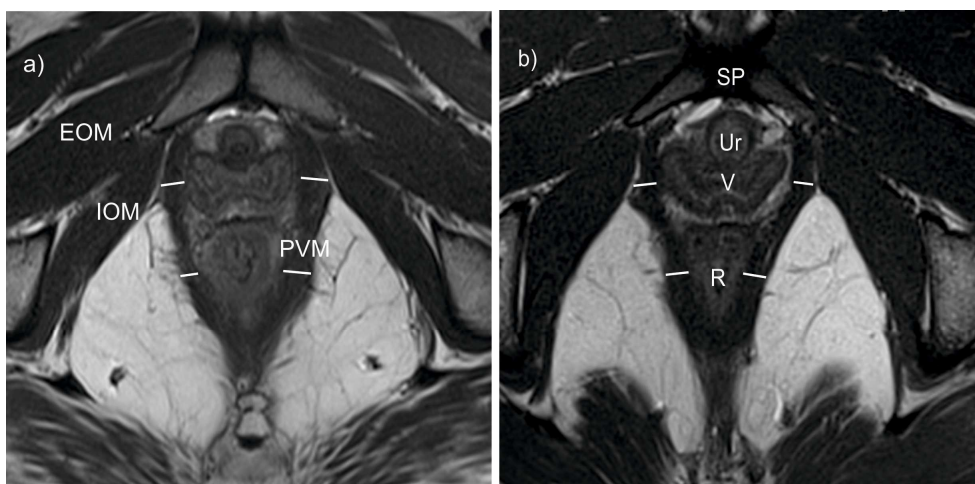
Magnetic Resonance images in the axial plane of a continent (a) and incontinent woman (b). The measurements of muscle thickness were made at the level of the midvagina and the anal
